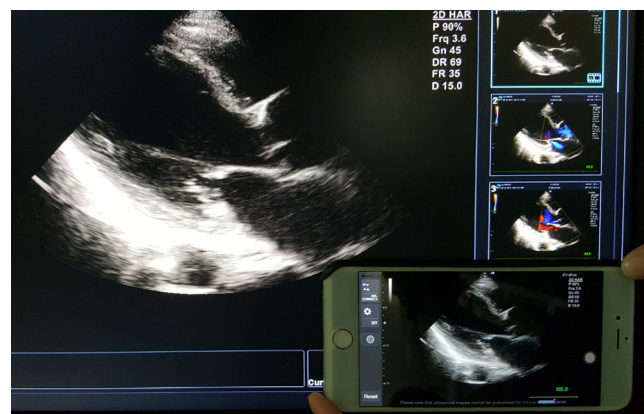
Screenshot of original image on LCD monitor of ultrasound machine and the transmitted image on smartphone display: The resolution of a single frame of echocardiography video is reduced by approximately 20 %
